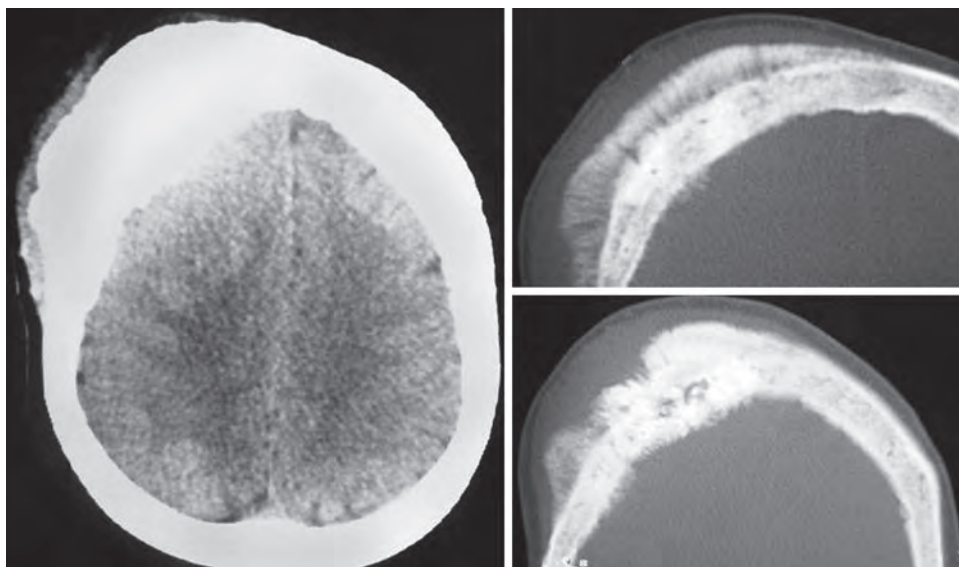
Plain CT scan and bone cuts showing hyperostosis in a case of frontal convexity meningioma
